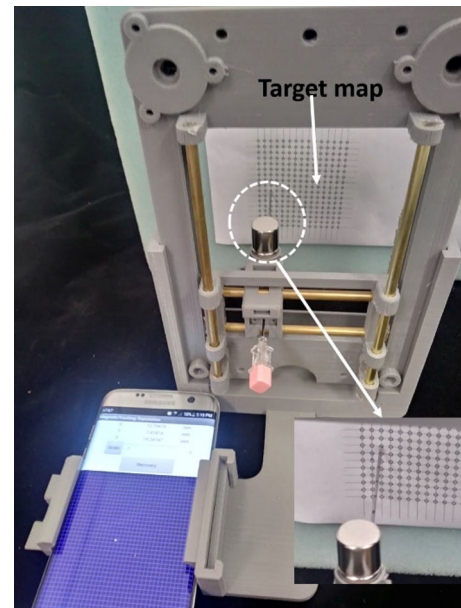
(a) 3D model of the operation platform. (b) 3D printed operation platform with a working plane in CT coordinate system.
